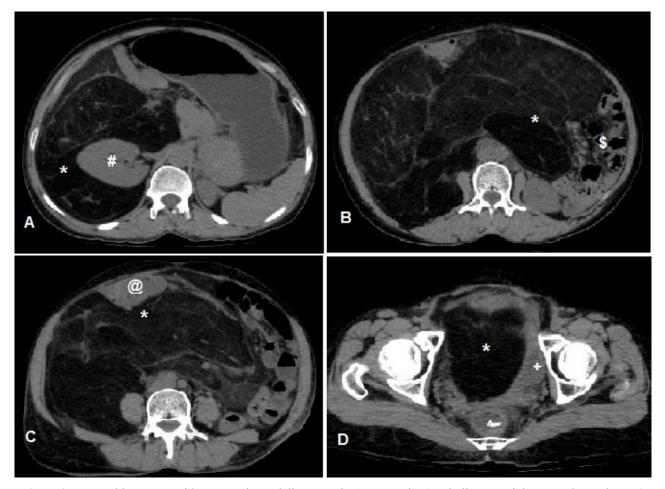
A 35 year old woman with retroperitoneal lipomatosis (same patient). Findings: Axial Non enhanced CT (NECT) images taken cranio-caudally demonstrate presence of diffuse fat attenuation lesion with some septations within it located in the retroperitoneum and pelvis (Figure 2A, 2B, 2C, 2D asterix). It is also seen displacing the right kidney (Figure 2A #) anteriorly and medially, small bowel loops (Figure 2B \$) laterally on left, transverse colon (Figure 2C @) anteriorly and causing compression and mild displacement of urinary bladder (Figure 2D +) and compression of rectum (Figure 2D ^). Technique: Axial NECT images of the abdomen and pelvis on 16 slice MDCT (Multi detector CT) machine, slice thickness 5mm, KV 120 and mAs 250.
